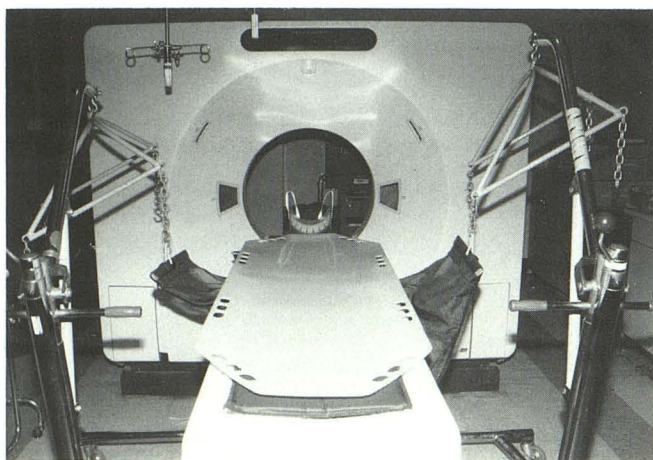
Apparatus for supporting patient. White plastic buckboard on which patient rests is supported by a sling suspended from two Hoyer lifts that flank CT table.
